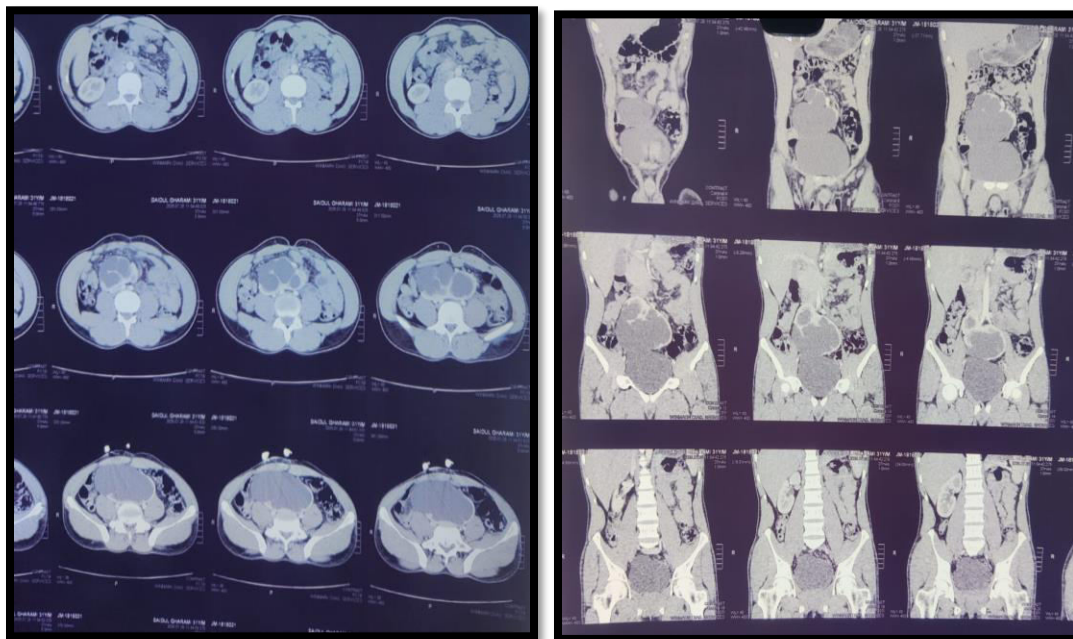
Contrast enhanced CT scan showing hydronephrotic left ectopic pelvic kidney
